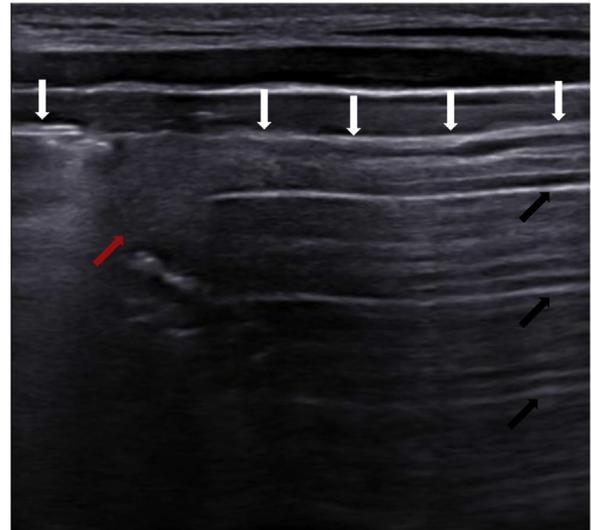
On cervical ultrasound, the longitudinal scan of the right thyroid lobe partly shows the apical region of gland (red arrow) due to the acoustic barrier. The latter is created by the presence of air in the tissues (white arrows) producing the ultrasound artifacts, defined as “A-lines” (black arrows).
